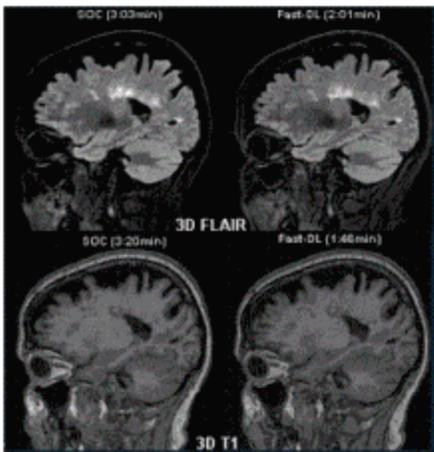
SubtleMR™ [Left/right: SOC/FAST-DL] [Top/bottom: 3D FLAIR/3D T1].
